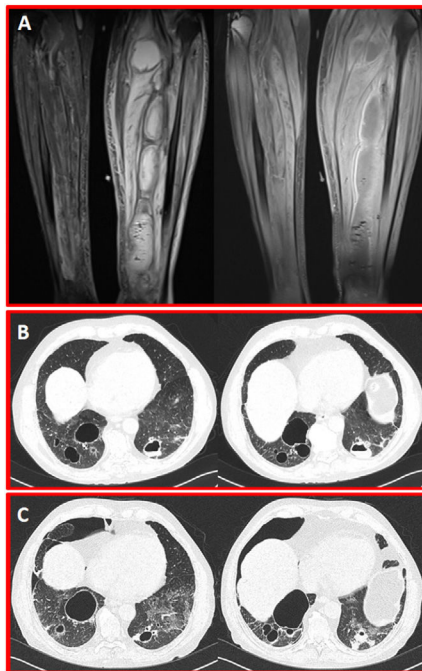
(A) Coronal proton density and postcontrast T1-weighted MR images show giant intramuscular abscesses in the posterior of the left cruris. (B) Axial CT scans in parenchyma window show multiple cavitary septic embolisms in both lungs. (C) Control CT scans five days after from the presentation scan reveal the right pneumothorax secondary to septic embolism.
